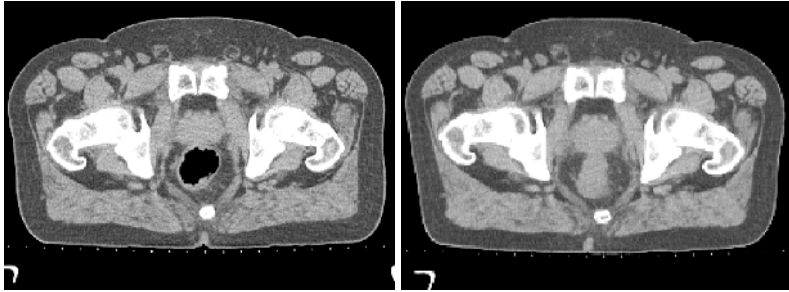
Axial CT slice of the same patient acquired on different days, showing the effect of bowel gas
